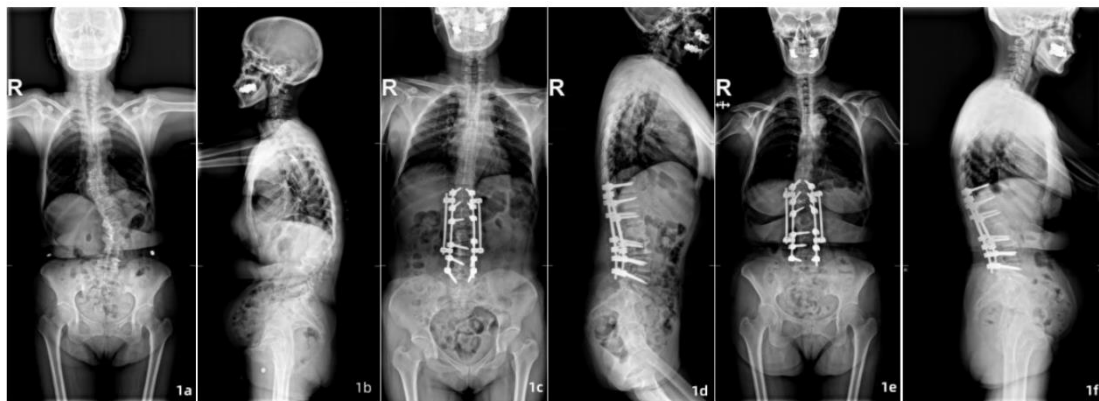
A 56-year-old female with Lenke-Silva grade IV adult degenerative scoliosis. Preoperative anteroposterior and lateral radiographs (a,b) postoperative radiographs (c, d) demonstrated significant correction. Final follow-up radiographs (e, f) confirmed maintained correction, solid osteotomy union, and stable instrumentation.
